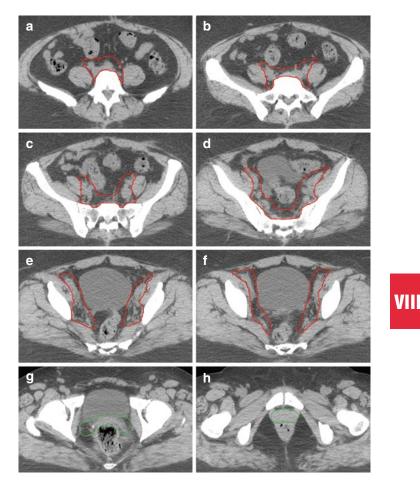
Example pelvic nodal IMRT clinical tumor volumes on representative axial CT slices: (a) upper common iliacs, (b) midcommon iliacs and presacral area, (c) lower common iliacs and presacral area, (d) upper internal and external iliacs and presacral area, (e and f) internal and external iliacs, (g) vagina and parametrium, (h) vagina
